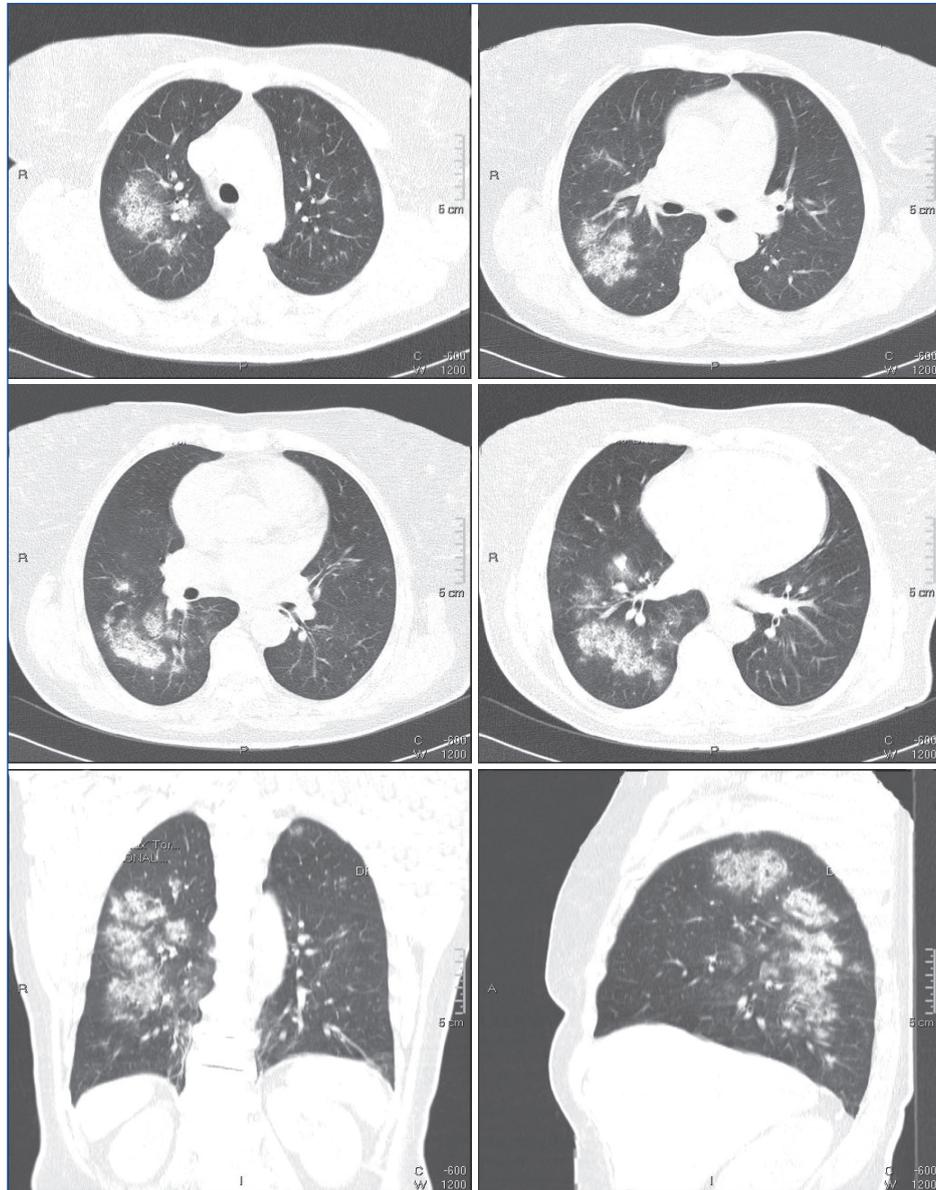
Thoracic CT showing bilateral multifocal consolidation along the bronchovascular bundle with mild ground-glass opacity, particularly in the right lung; axial (first 4 images), coronal and sagittal planes, respectively.
